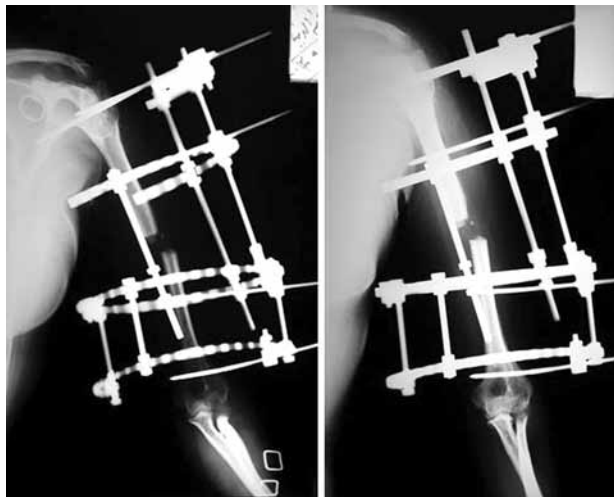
(b, c): Plain radiograph of the same patient with malaligned distal fragment causing wrist drop
